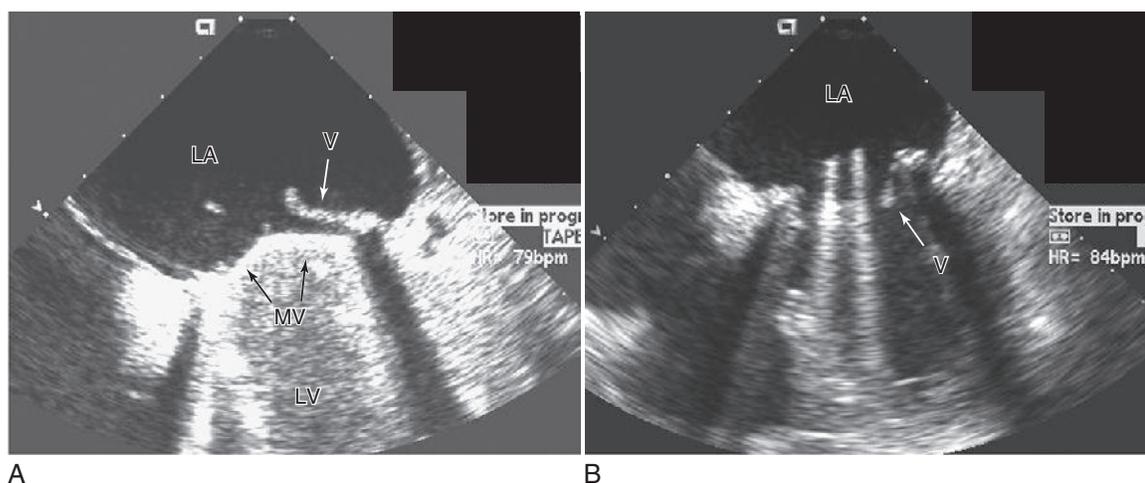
Transesophageal echocardiogram demonstrates a vegetation (*arrow*) adherent to the ring of a bileaflet, tilting-disk mitral valve prostheses. A, In systole, the leaflets are closed with the vegetation seen in the left atrium. B, In diastole, the leaflets are open, with the vegetation prolapsing into the left ventricle. Transesophageal echocardiography is the diagnostic test of choice for assessing prosthetic mitral valves because the esophageal window allows unimpeded views of the atrial surface of the valve. Video 4-4 shows a dynamic transesophageal echocardiographic image. LA, Left atrium; LV, left ventricle; MV, prosthetic mitral valve disks; V, vegetation. (Courtesy Sheldon E. Litwin, MD, Division of Cardiology, University of Utah, Salt Lake City, Utah.)
